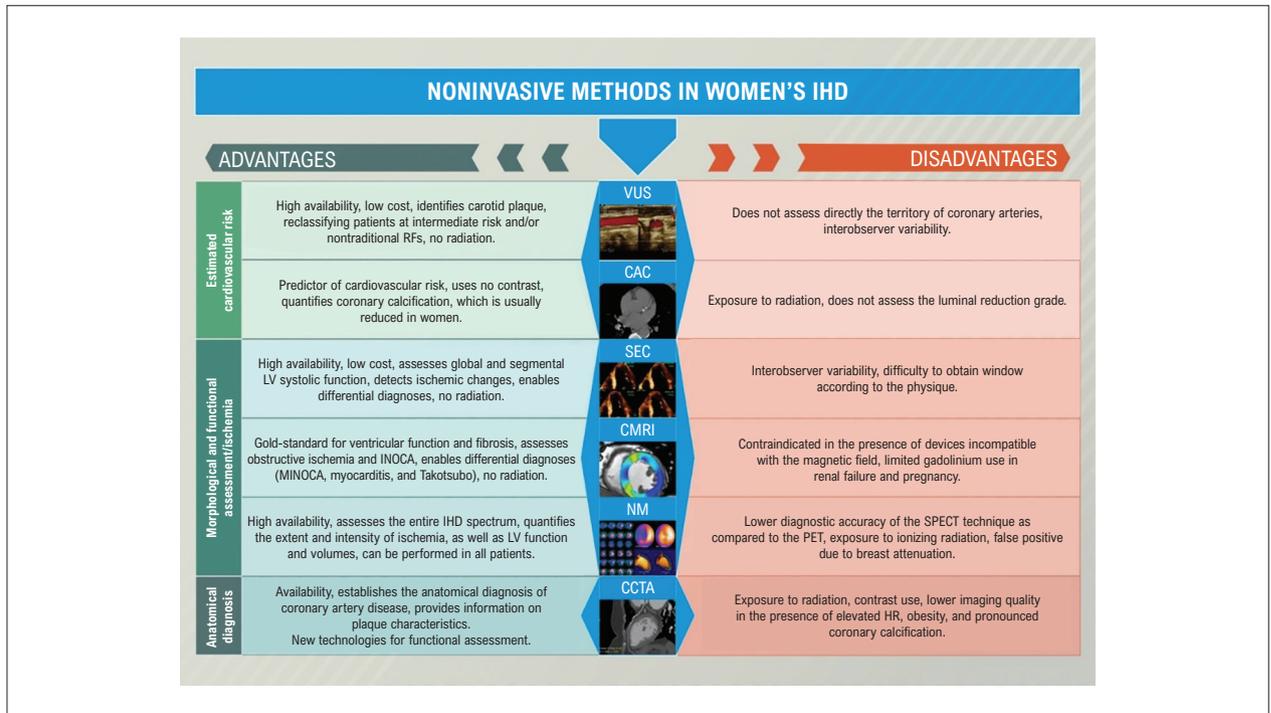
Importance of noninvasive imaging methods in women’s ischemic heart disease. CAC: coronary artery calcium score; CCTA: coronary computed tomography angiography; CMRI: cardiac magnetic resonance imaging; HR: heart rate; IHD: ischemic heart disease; INOCA: ischemia with nonobstructive coronary arteries; LV: left ventricular; MINOCA: myocardial infarction with nonobstructive coronary arteries; NM: nuclear medicine; PET: positron emission tomography; RF: risk factor; SEC: stress echocardiography; SPECT: single photon emission computed tomography; VUS: vascular ultrasound (carotid).
